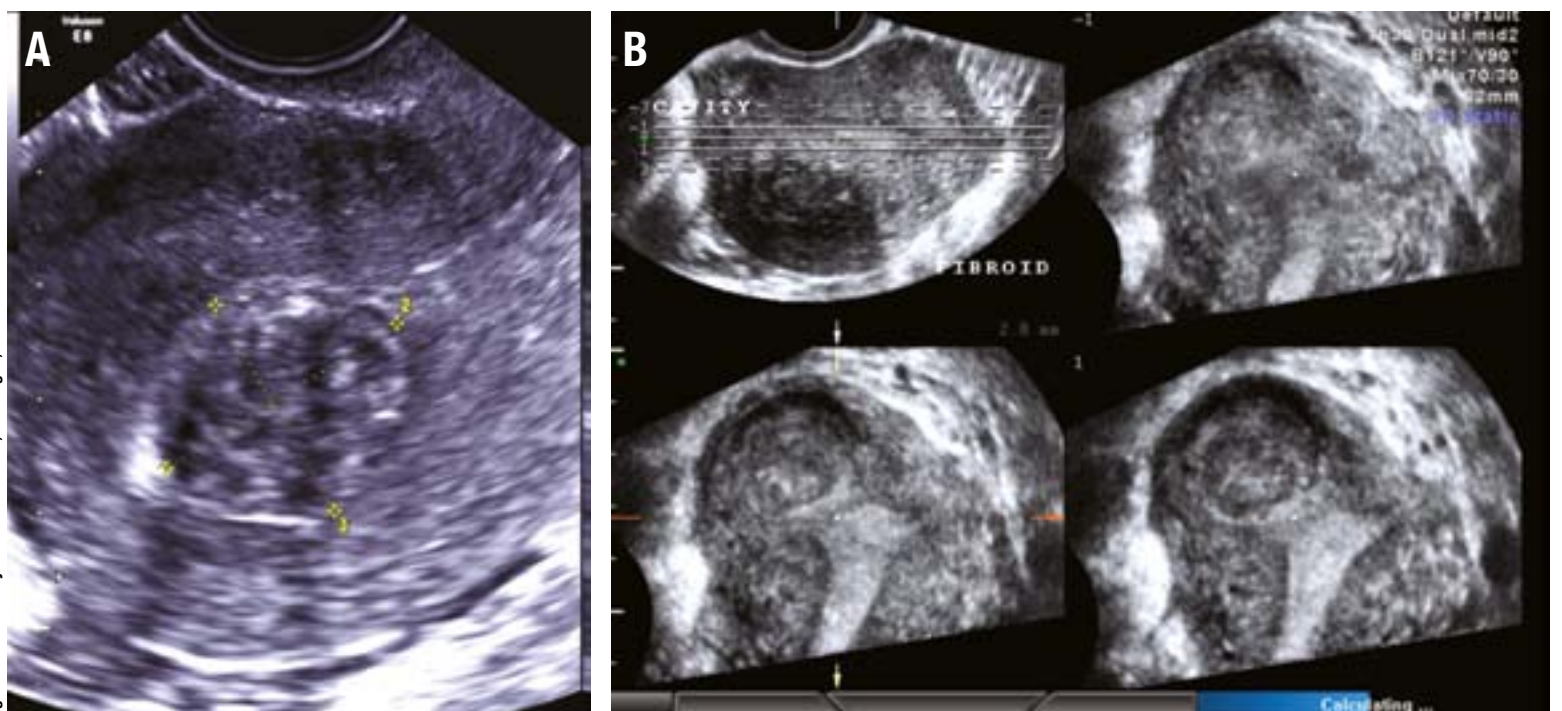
Classification of fibroid by location. A: Transvaginal ultrasound showing a submucosal fibroid distorting the endometrial cavity. B: 3D ultrasound technology is useful in displaying the location of this submucosal fibroid indenting the cornua in the fundal region.
